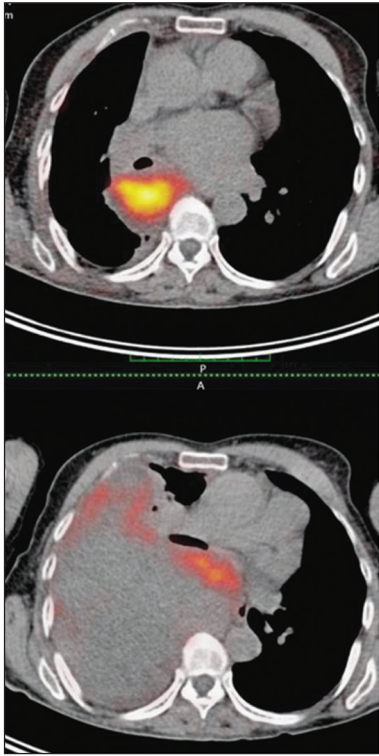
Ga-68 DOTATATE positron emission tomography/computed tomography transaxial fusion images of the patient before and after the operation (below and above) respectively.
